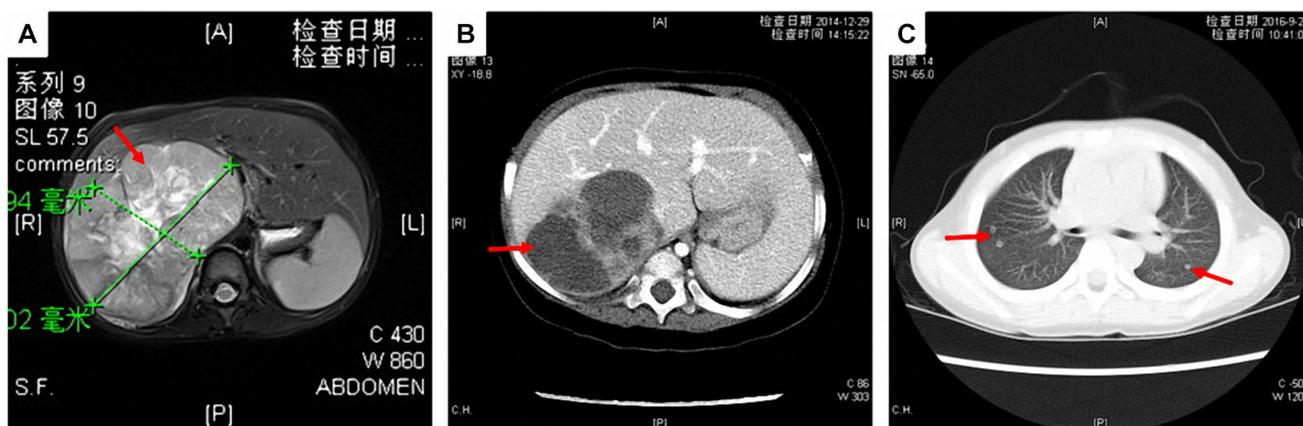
a Computed tomography (CT) shows a thin capsule and central necrosis or hemorrhage in the primary lesion. b Hepatic metastasis. c Pulmonary metastasis
